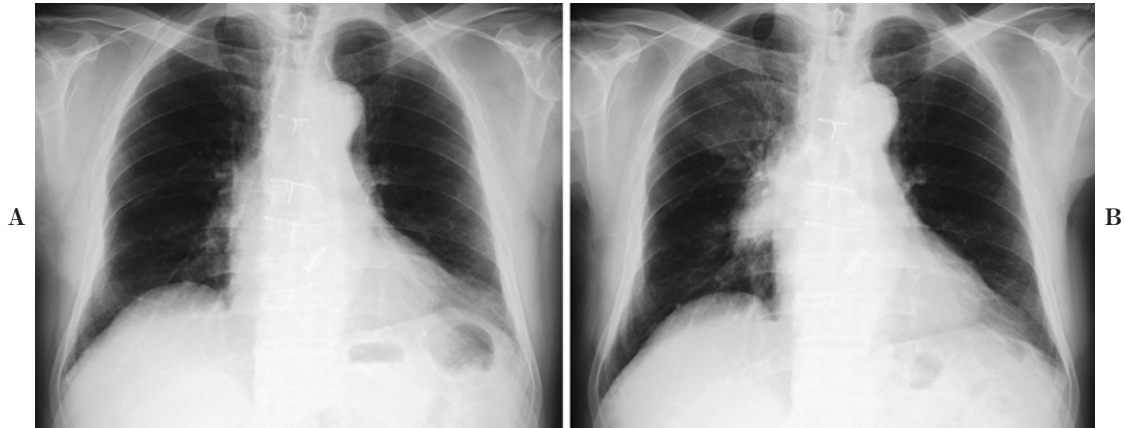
A chest radiograph 6 months before admission showed no abnormalities in the lung (A). A chest radiograph on admission showed a right-side hilar mass and ill-defined infiltrate in the right upper lung field (B).
